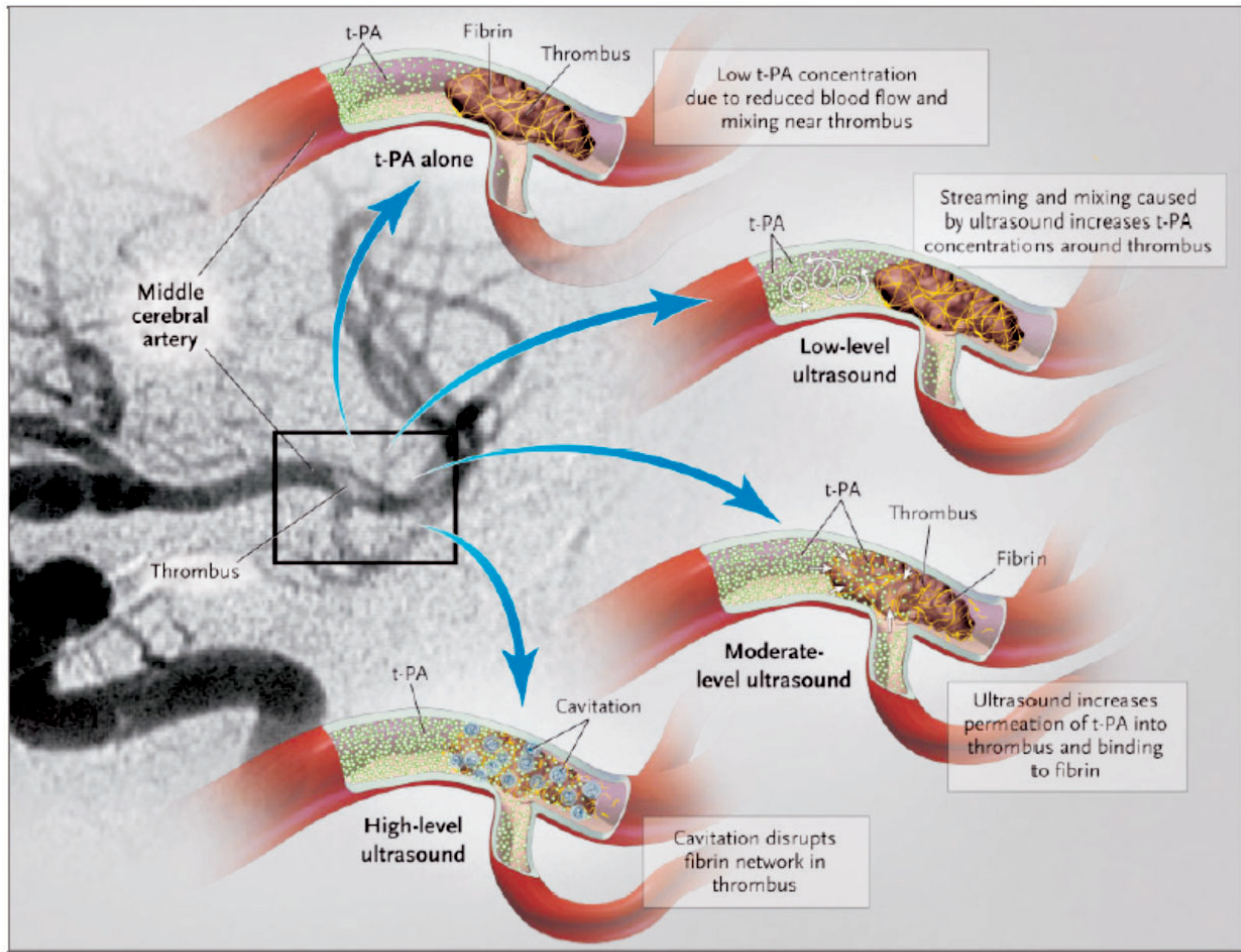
Potential mechanisms of ultrasound-enhanced thrombolysis (reproduced with permission from Polak JF. *N Engl J Med* 2004;351:2154-5).
